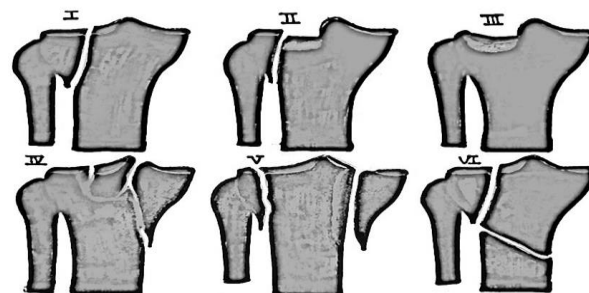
Schatzker classification of tibial plateau fractures (TPFs) based on anteroposterior (AP) view in plain radiographs
